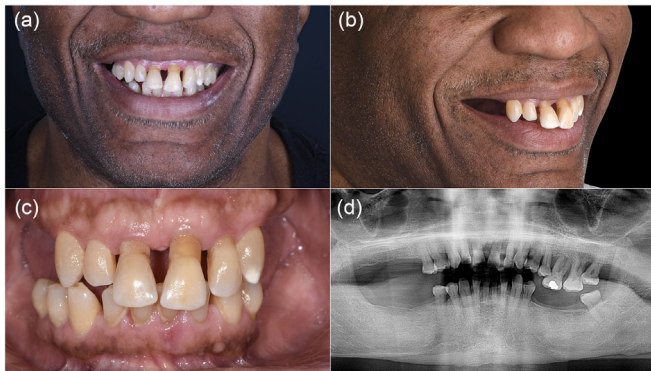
Pretreatment presentation. (a) Extraoral view of smile, frontal view. (b) Extraoral view of smile, lateral view. (c) Intraoral view. (d) Pretreatment panoramic radiograph.
